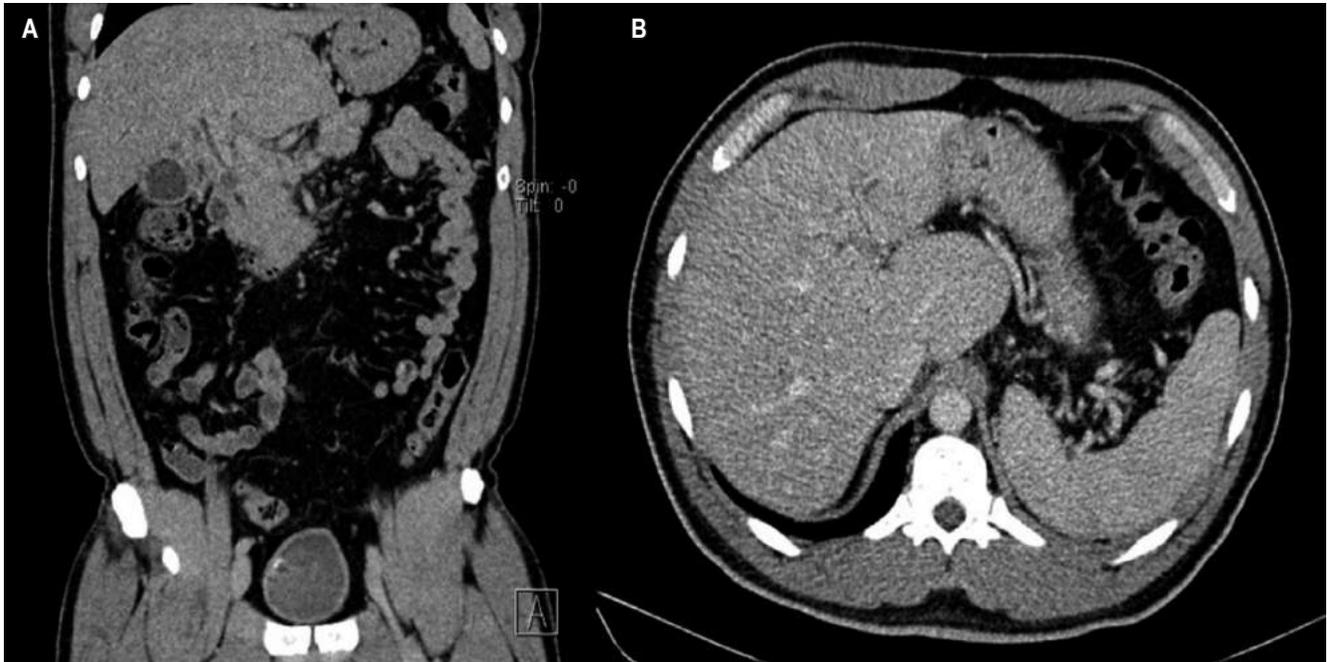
A. CT scan of the abdomen contrasted with findings of chronic liver disease and multiple venous collaterals. B. Findings of liver disease (nodularity of liver lobes) and splenomegaly. Source: Authors' archive.
